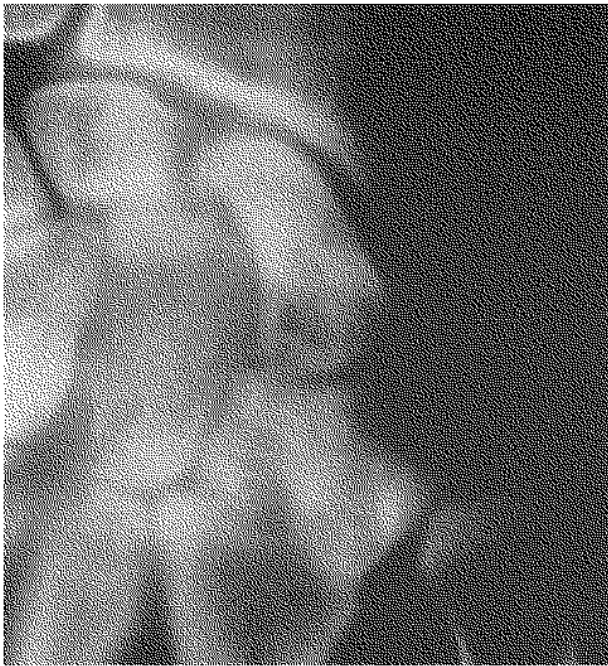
Case 2 typical X-ray finding.
